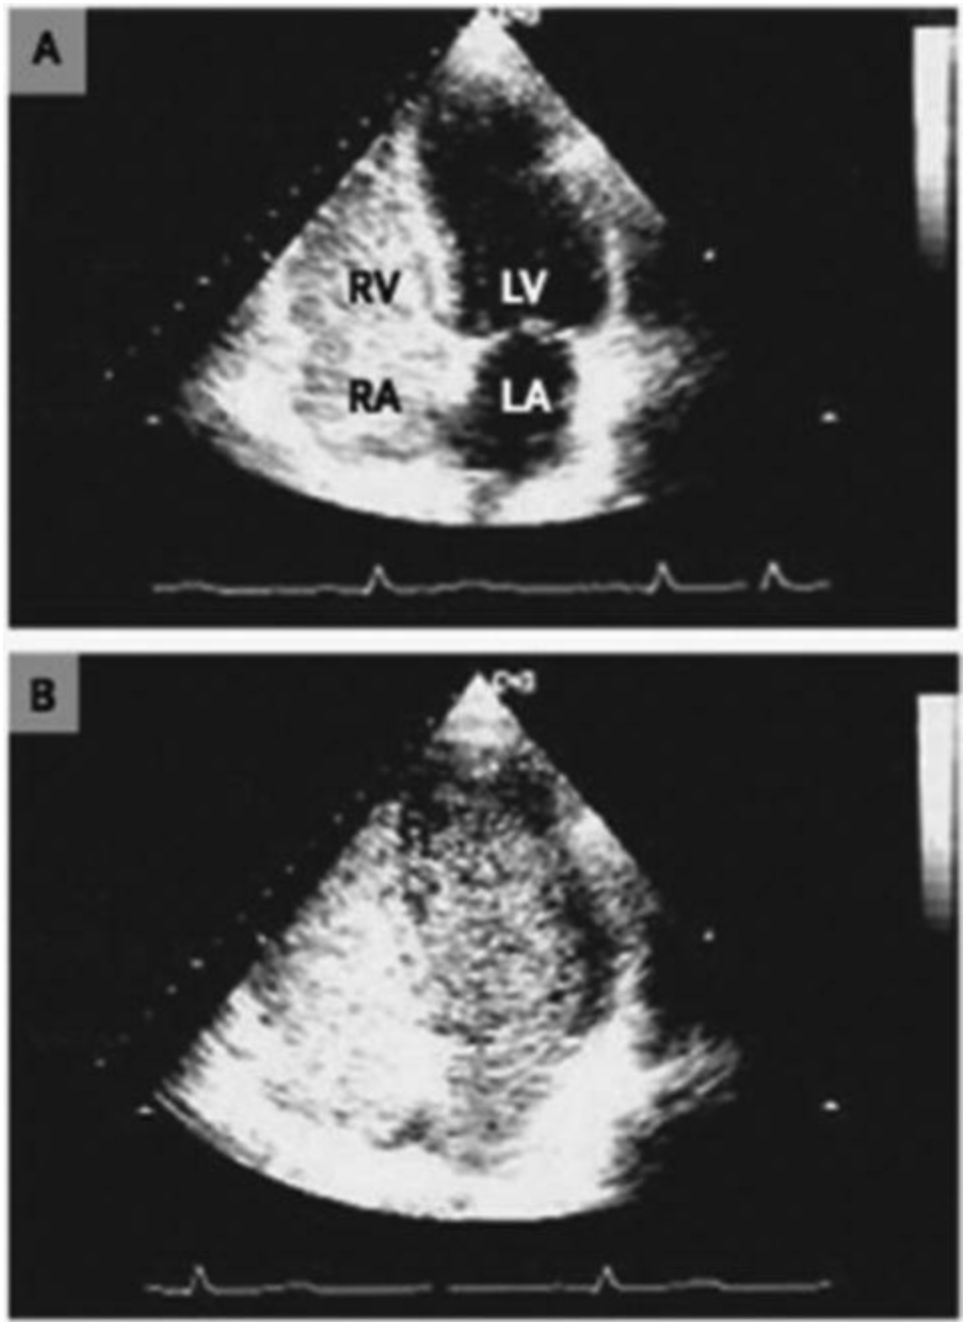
Transthoracic echocardiogram demonstrating a delayed passage—5 to 6 beats—of echogenic material from the injection intravenously of agitated saline, from right to left heart
